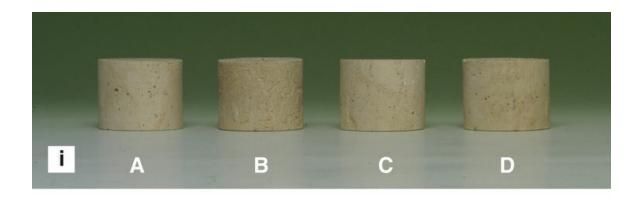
(i) Front view and (ii) plan view of various cylinders of similar shape but made of different materials: (A) plaster of Paris, (B) hollow plastic, (C) metal, and (D) wood. (iii) Radiographs of the cylinders show how objects of the same shape, but of different materials, produce different radiographic images.
